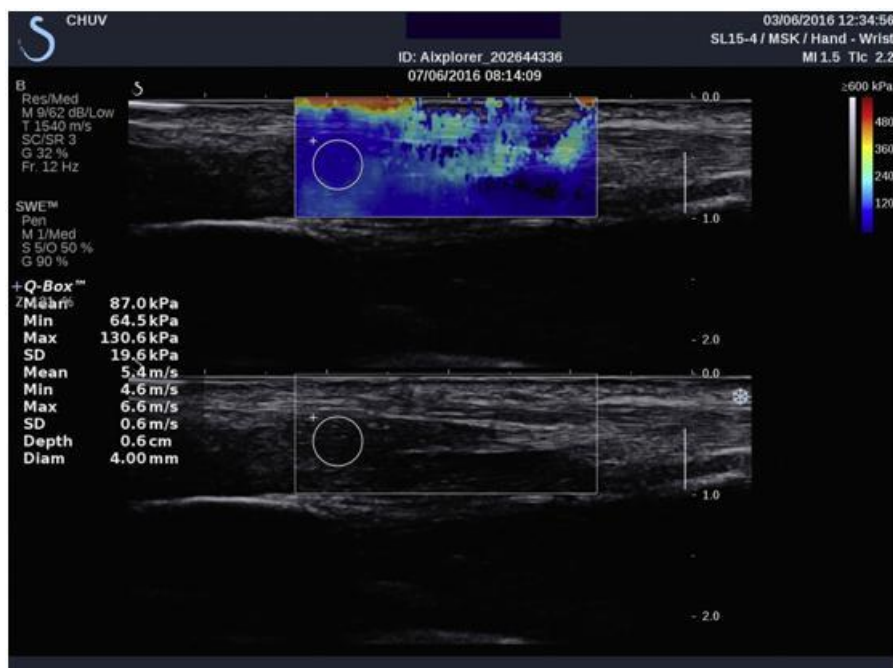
B-mode ultrasound (low) and elastographic (high) recording during the 5th stage of the transfer (P).
